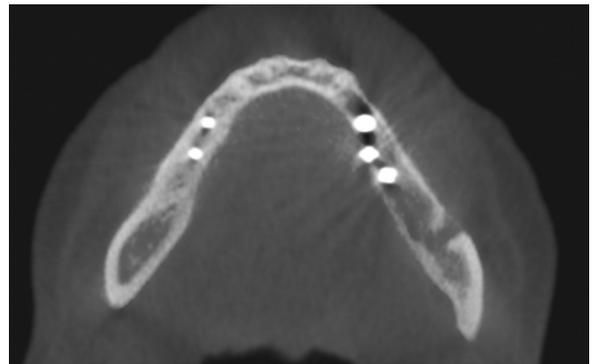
Two-year follow-up computed tomographic scan of a patient in whom the left hemimandible was rehabilitated with a fixed, implant-supported prosthesis after a “double sandwich” osteotomy of the premolar and molar regions, and a lateralisation of the mandibular nerve. Note the harmonious contour of the buccal cortex in the axial view.
